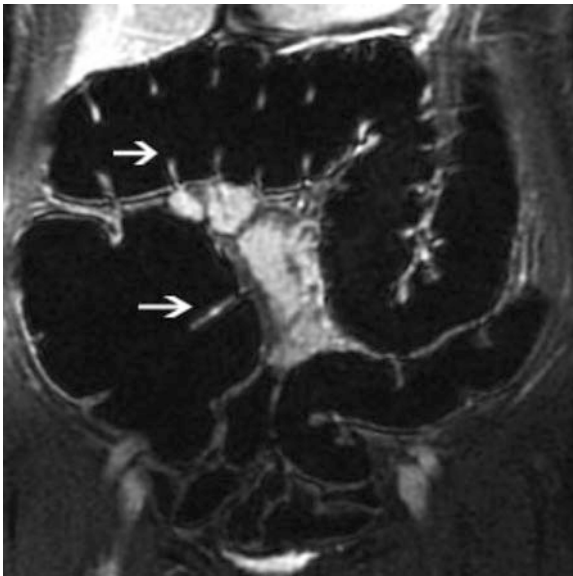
Dark lumen MRC: Coronal T1-weighted SPGR with twofold acceleration using ASSET post IV shows a well-distended colon with excellent visualization of the haustral folds (arrows). This image was acquired in 13 s
